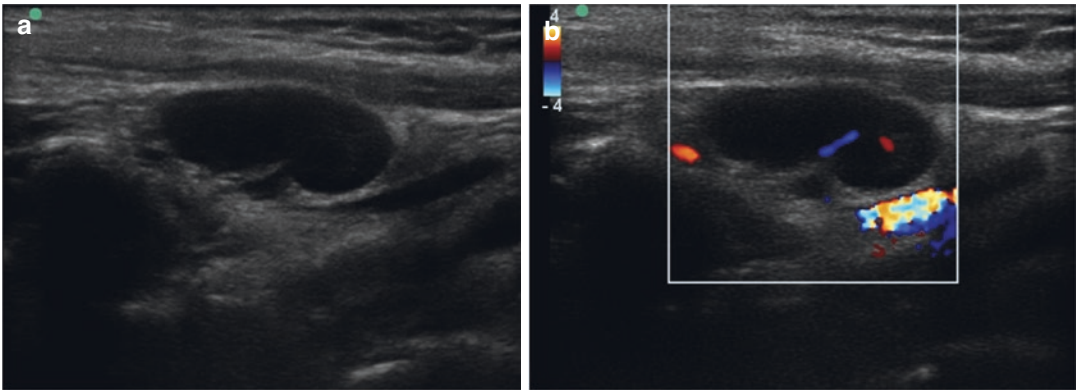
The characteristics of the lymph node with hyperechoic hilum (a) and positive color Doppler's signal (b) visualized in a pediatric patient
